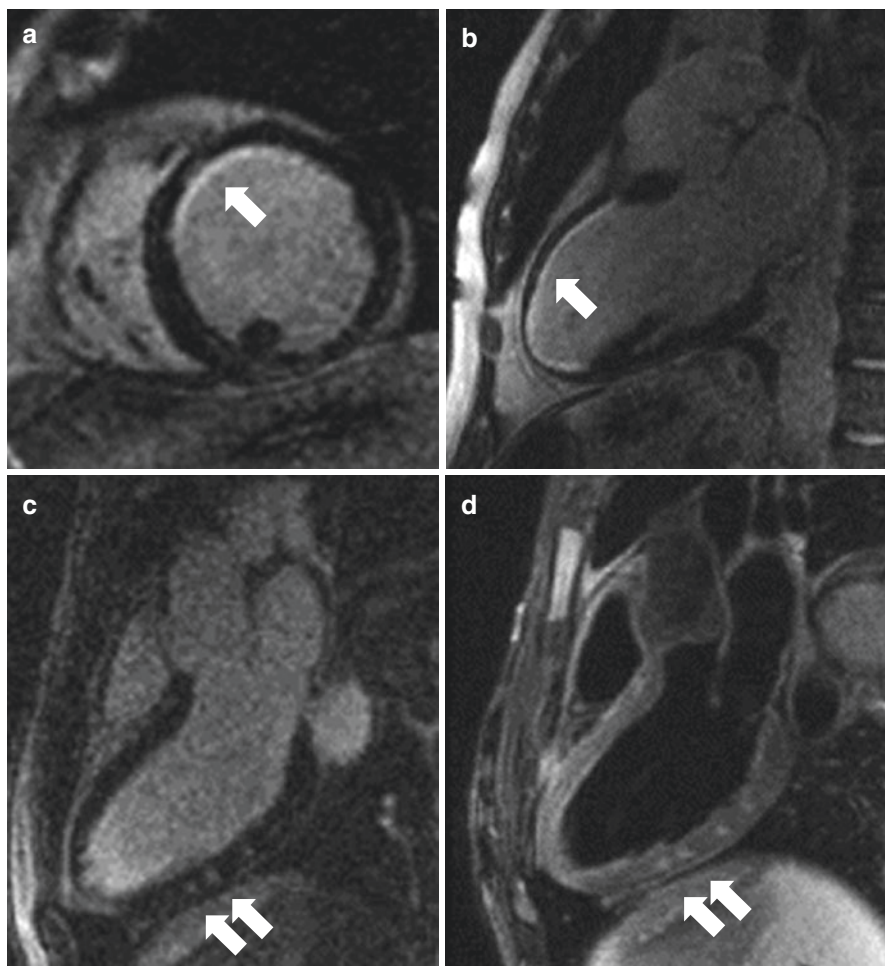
Different CMR patterns in ischemic heart disease and myocarditis. A typical case of subendocardial post-infarction scar (late gadolinium enhancement, LGE) is shown in (a) (post-contrast short-axis view) and (b) (post-contrast long axis view) at the left ventricular anterior and antero-septal walls (white arrow). On the contrary in myocarditis LGE is detectable with a patchy, non-coronary related pattern, in this case at the infero-lateral wall (white arrow on c, post-contrast long axis view); acute inflammation is confirmed by the presence of edema on T2-weighted sequences at the same areas of LGE detection (white arrow on d)
